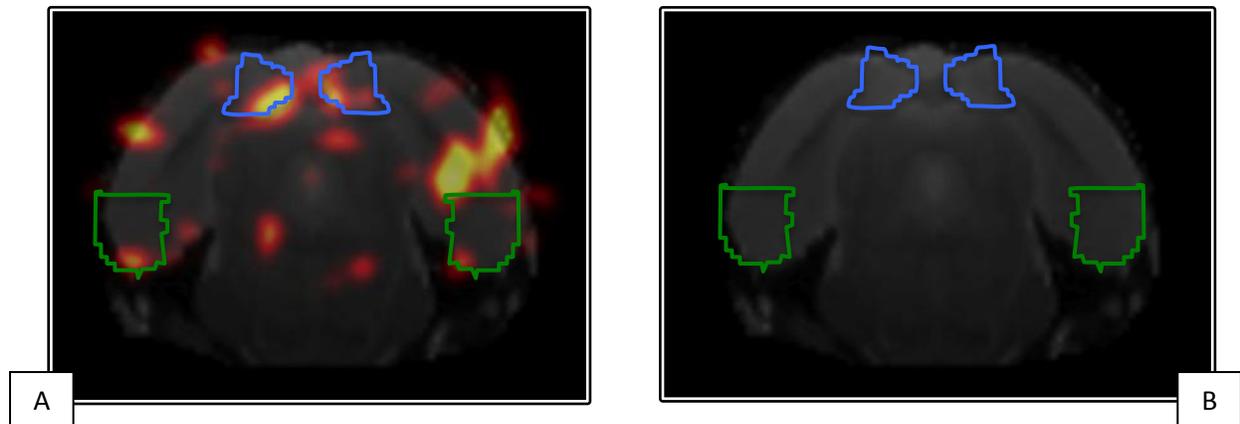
PET-FDG image of the entorhinal and retrosplenial cortex.
